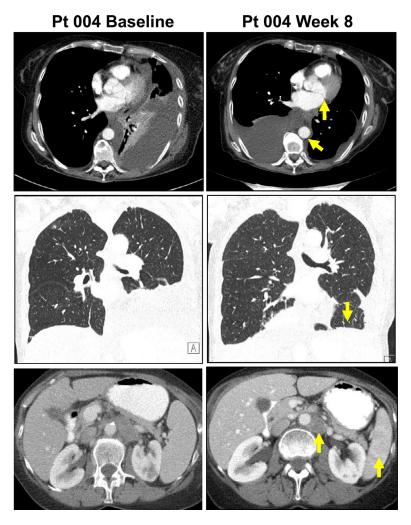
Example of serial CT-scan results: Patient 004 had disseminated angioimmunoblastic T-cell lymphoma relapsed after first-line Brentuximab vedotin and second-line autologous stem cell transplantation with busulphan/cyclophosphamide/etoposide conditioning. Yellow arrows indicate improvements with THU/decitabine treatment in pericardial/pleural effusions (top, middle panels), periaortic lymphadenopathy (top, bottom panels) and splenomegaly (bottom panel).
